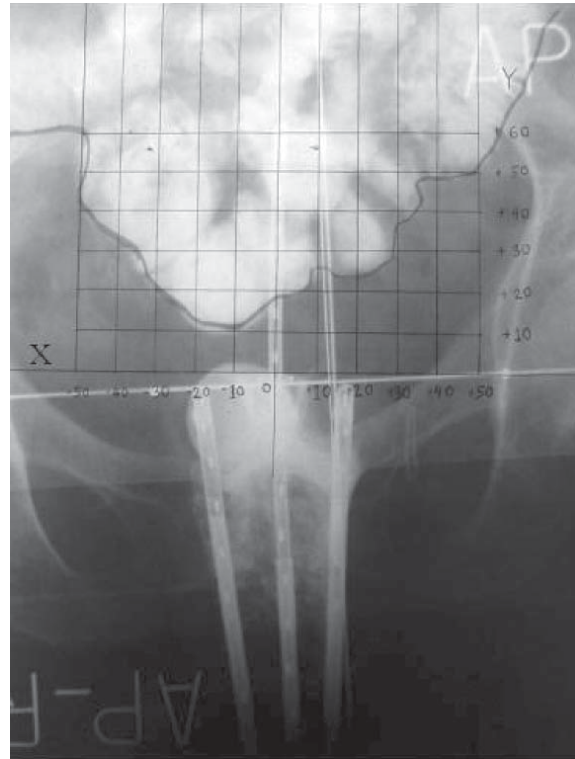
Show radiograph in antero-posterior view with calculated points in X and Y axis (before bladder distension)
